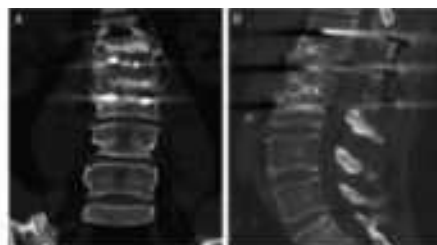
Example of posterior lumbar interbody fusion. A and B, Coronal and sagittal computed tomographic scans of a 48-year-old man, 10 months after the procedure.
